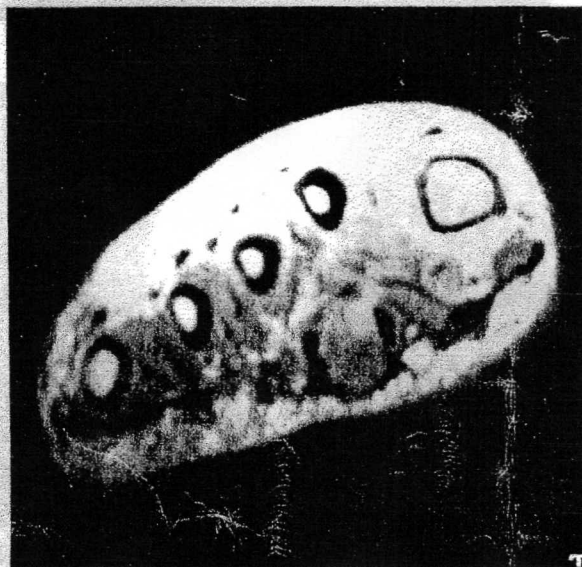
T-2 weighted MRI images reveal a 1-cm mass deep to the plantar fascia.
